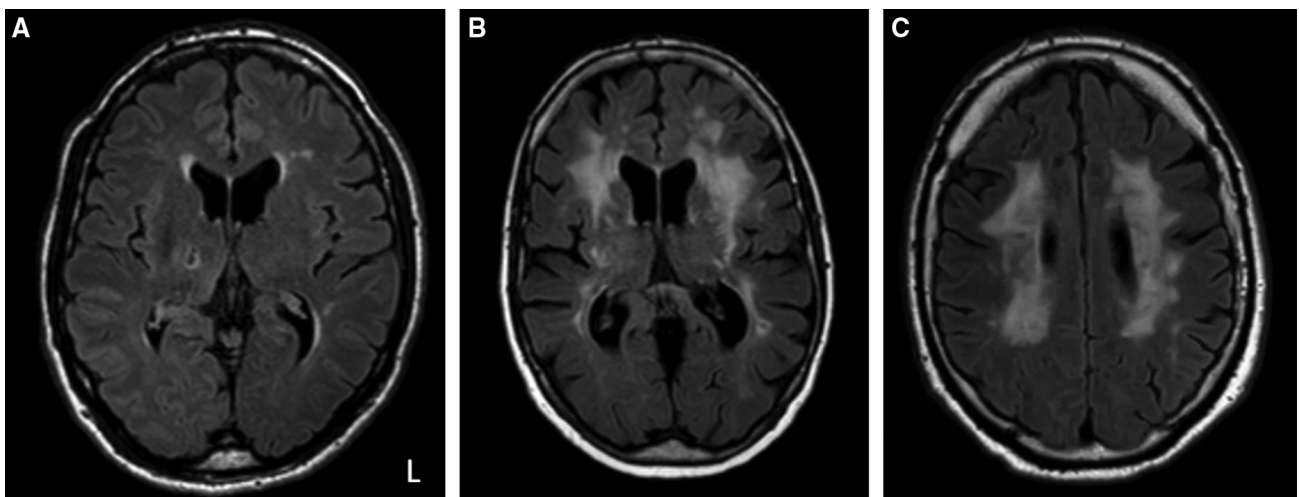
MRI scans showing typical examples of WMHs of presumed vascular origin. (A) Punctate deep subcortical WMH in the left hemisphere and periventricular caps. This scan is Fazekas grade 1, on the Fazekas scale of WMH severity (range: 0–3). In the right thalamus, a lacune can be seen. (B, C) Two examples of severe confluent WMH. Note that borders between periventricular and deep subcortical WMHs become difficult to define. Scans B and C are Fazekas grade 3. Scans A–C are FLAIR sequences. Figure provided by GJ Biessels. Abbreviations: MRI, magnetic resonance imaging; WMHs, white matter hyperintensities; FLAIR, fluid-attenuated inversion recovery.
